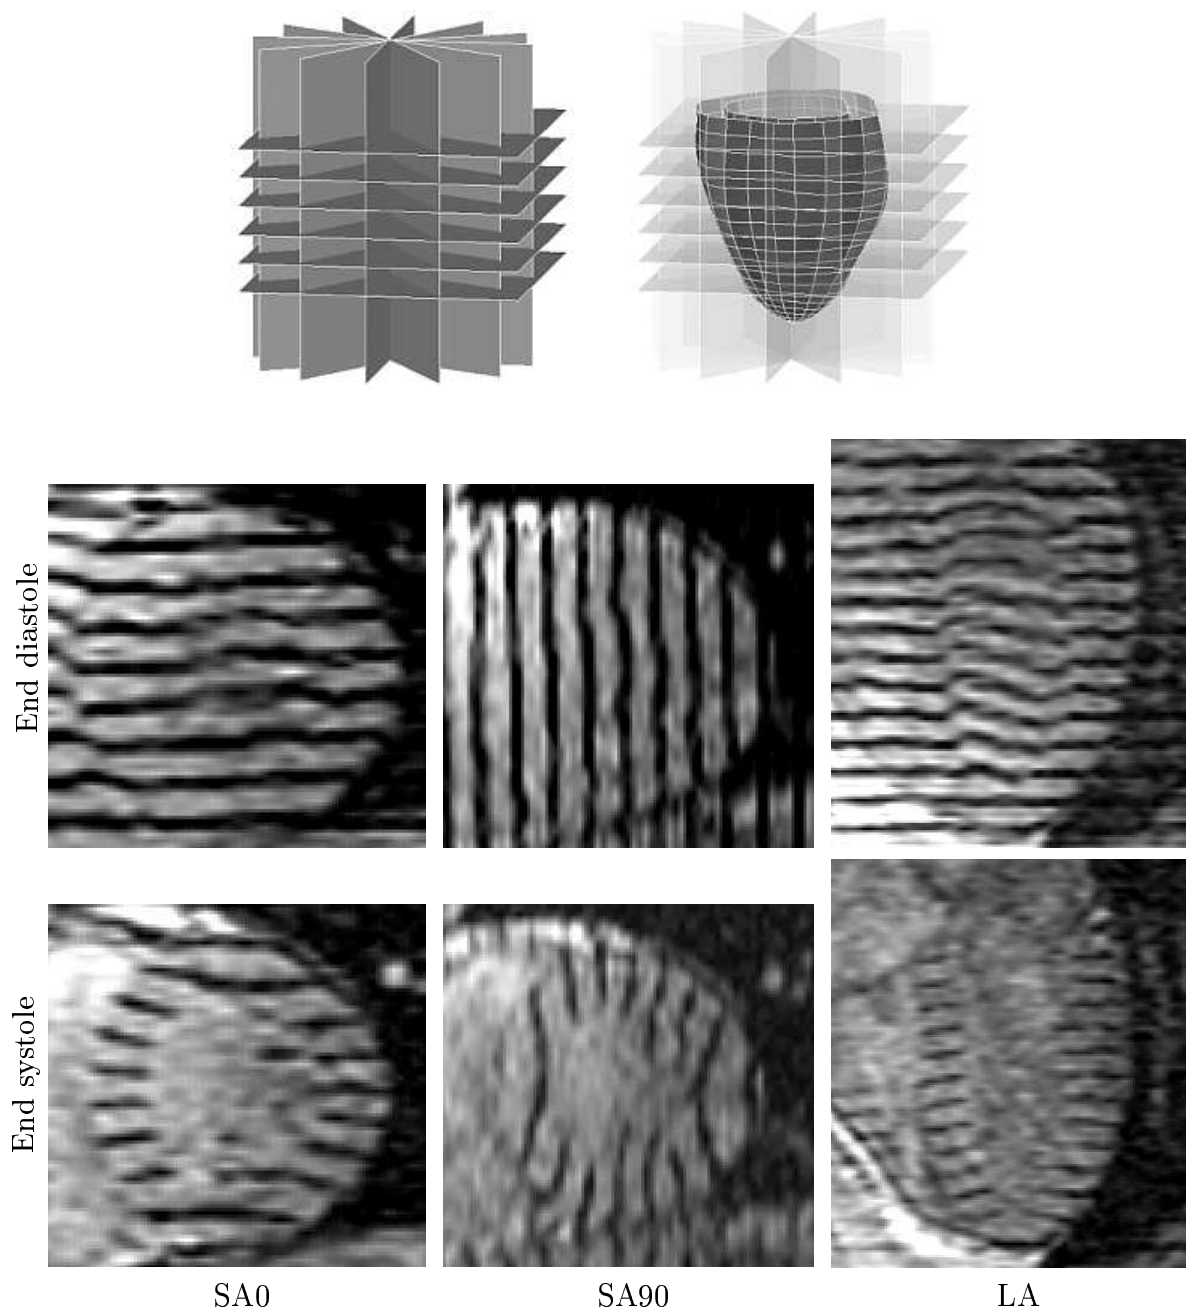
The planar tagged MR images. Top, the region of interest in the short axis and long axis planes. The LV mesh used for the display is showed on the right with the ROI in transparency. Bottom, some images of the LV at end diastole (top) and end systole (bottom) with three different tag directions, from left to right (two short axis and one long axis).
